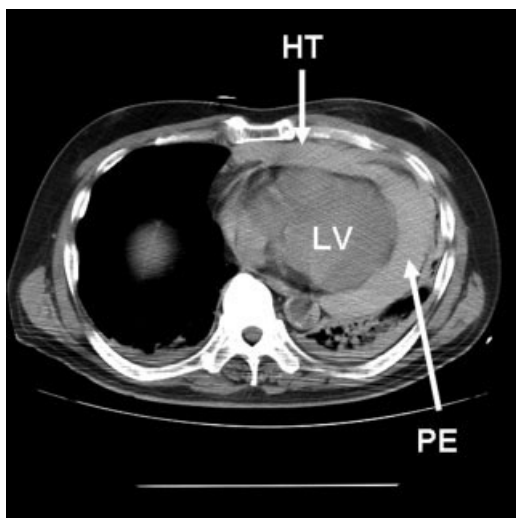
Plane computed tomography clearly showed a large amount of pericardial effusion around the left ventricle with a small hematoma abut on the epicardium caused by pericardiocentesis. HT, hematoma abut on epicardium caused by pericardiocentesis; PE, pericardial effusion; LV, left ventricle.
